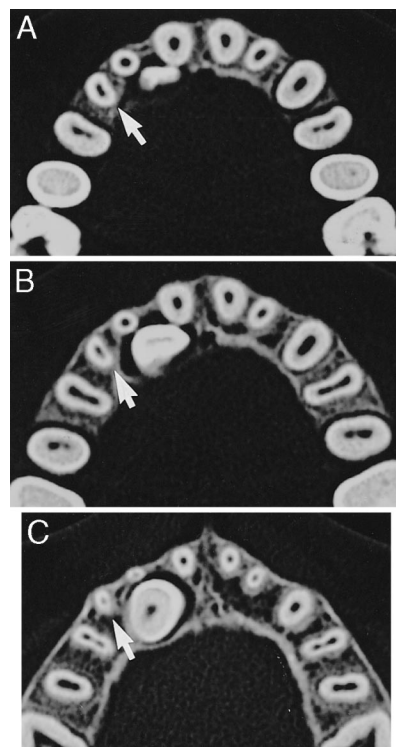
Findings in a 12-year-old girl on axial computed tomography (CT) scans. No. 13 is erupting with mesial inclination and lingually to No. 12 and No. 11. The crown of No. 13 is touching No. 11 (A, B). The dental follicle of No. 13 is slightly enlarged and has resorbed the periodontal contours of the roots of No. 11 and No. 12 on the side facing the follicle. No root resorption is seen. The root of No. 53 is separated from the dental follicle of No. 13 by bone (arrows), and the root of No. 53 is intact.
